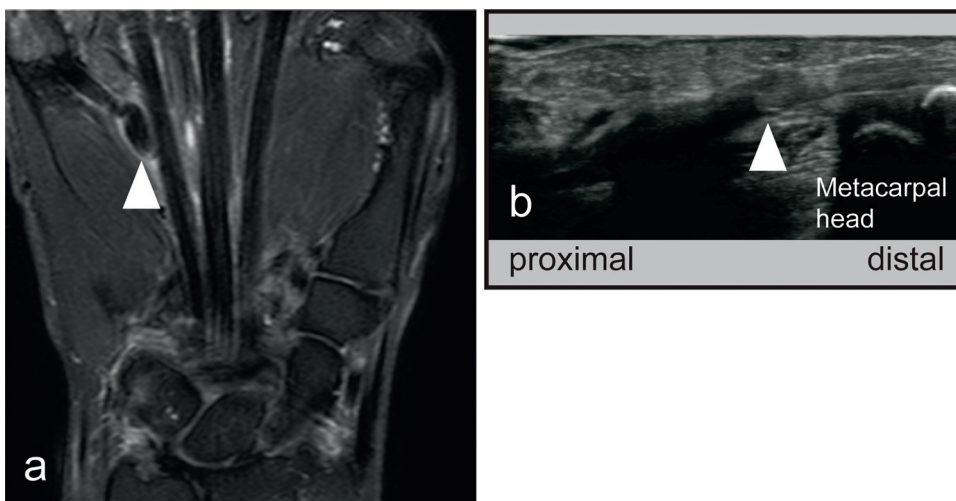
(a) MRI (arrow head: distal stump of the FDP of the little finger) (b) ultrasound image (arrow head: Distal stump of the FDP of the little finger).
